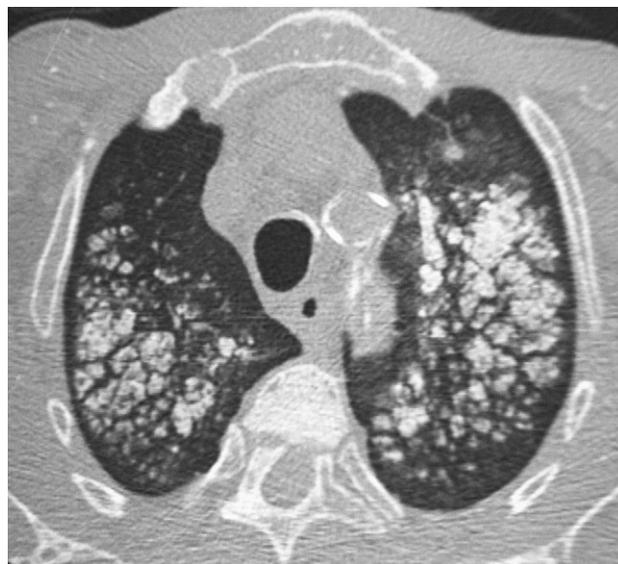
Axial CT scan demonstrating multiple bilateral centrilobular calcified nodules, mainly in the upper lobes.
